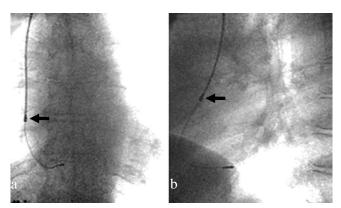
Proper lead placement (intraoperative X-ray) shown by postero-anterior view (a) and lateral view (b). Arrows indicate the lead ring located in the upper part of the right atrium. Note that a 8 cm distance between electrodes (tip-ring) of the lead is not excessive for a slightly enlarged heart.
